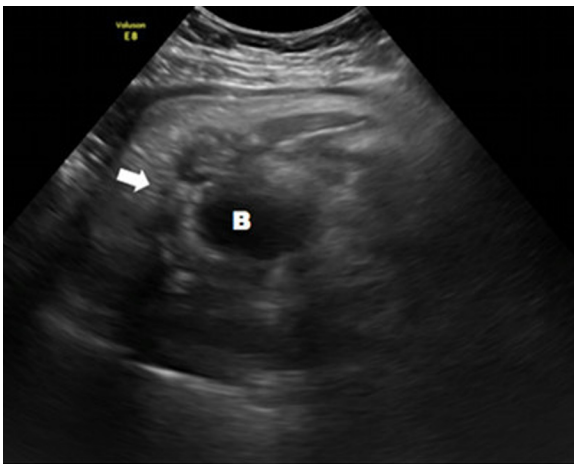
Transverse axial ultrasound image at level of fetal urinary bladder (B) demonstrates absence of sacrum (arrow).
